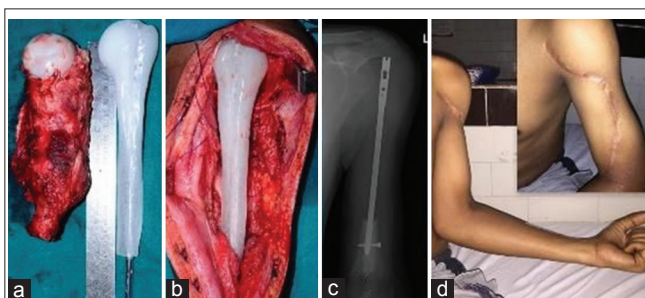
Excised tumor with custom made acrylic prosthesis (a), implanted acrylic prosthesis after tumor resection (b), plain radiograph with prosthesis in place at 1 year follow-up (c), clinical photograph showing satisfactory shoulder, elbow, and hand function at 1 year follow-up (d).
